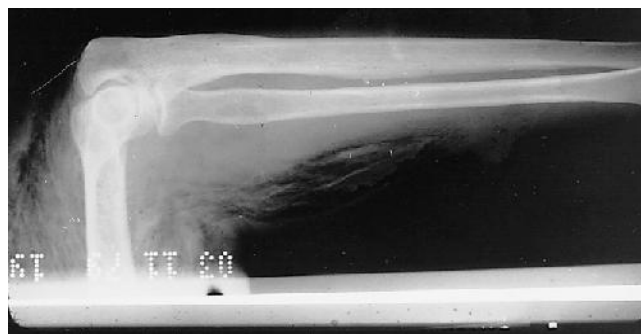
Radiograph of patient with clostridial myonecrosis shows gas in the tissues. (Courtesy J.W. Tomford, MD.)
